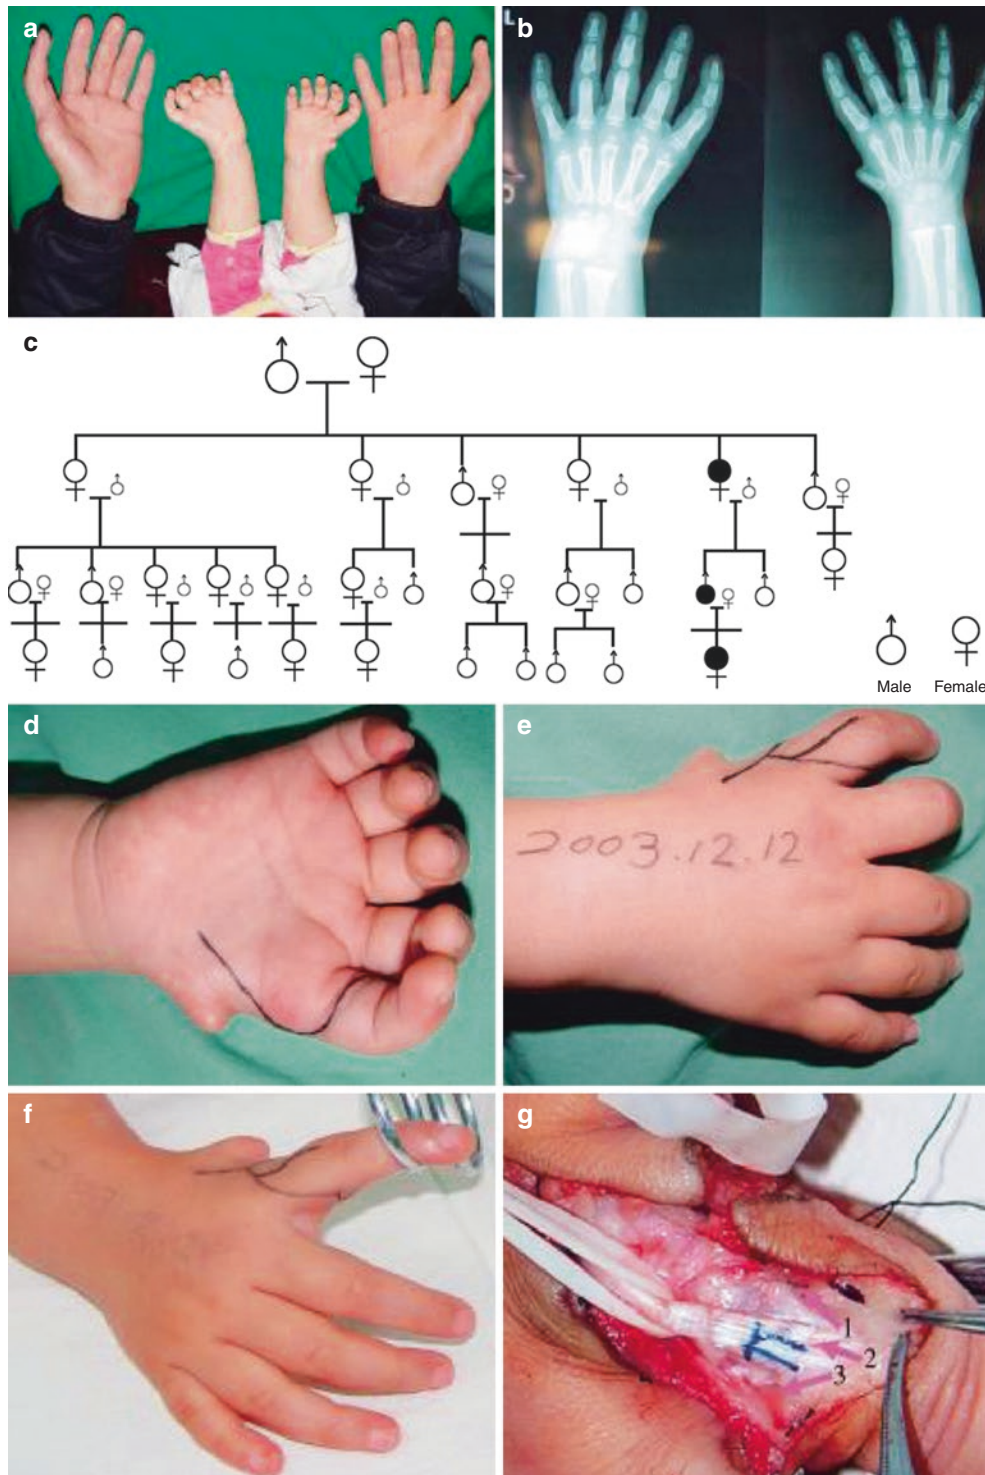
Case two. (a) A boy, with type VIb thumb dysplasia in the right hand and type VIa thumb dysplasia in the left hand; his father suffers from type VIa thumb dysplasia in both hands. (b) X-ray findings of the pediatric patient. (c) Genetic genealogy of the pediatric patient.
